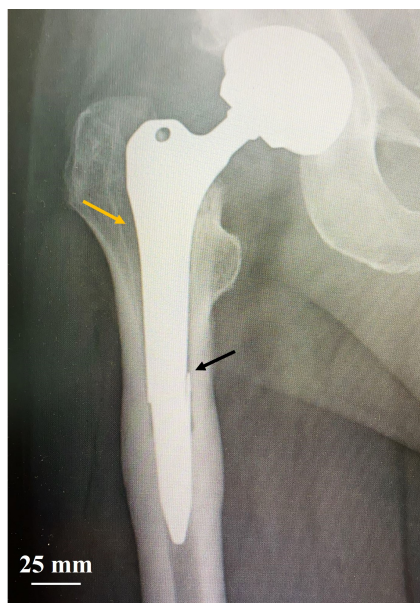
X-rays of a right THA failure in a Dorr type C femur as a consequence of stress shielding. The yellow lateral arrow indicates massive bone resorption in Gruen zone 1, while the medial black arrow indicates the stem fracture (image provided by Dr. Massimo Franceschini, orthopedic surgeon and head of Ortopedia e Traumatologia I, Istituto Ortopedico “Gaetano Pini”).
